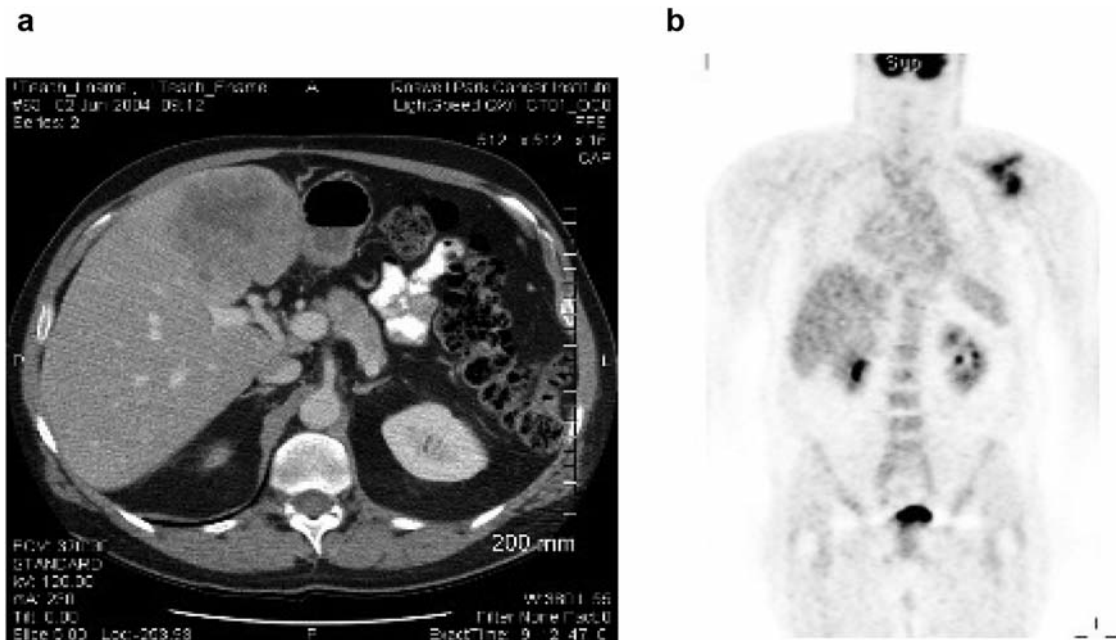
CT (a) and PET (b) scans showing a large left hepatic lobe mass and a left scapular metastasis before chemotherapy.
